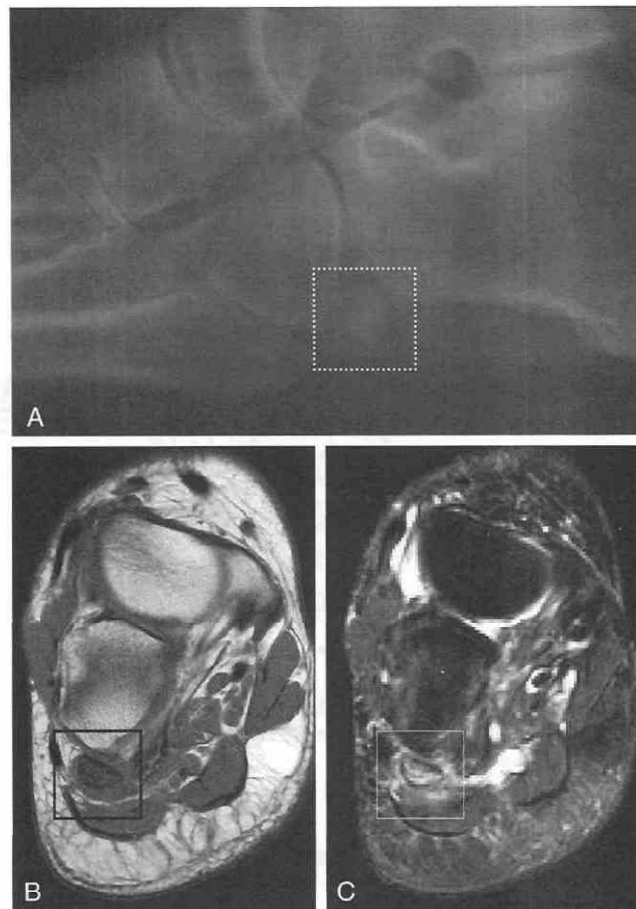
The patient is a 60-year-old woman with lateral point tenderness. *A*, Cone-down of a lateral radiograph of the midfoot. The os peroneum (dotted square) is perhaps slightly sclerotic, but this is a relatively subjective finding. *B*, Oblique coronal T1-weighted image demonstrates the os peroneum (black square). *C*, Fat-suppressed T2-weighted image, same position as *B*. Edema is present within and around the os peroneum (white square), indicative of "os peroneum syndrome."
